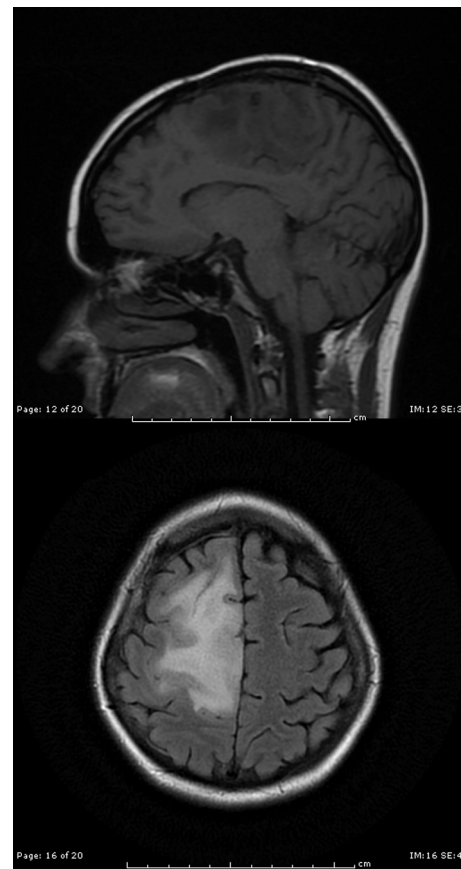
Sagittal T1-weighted (upper) and axial fluid attenuated inversion recovery (lower) MRI showing a non-enhancing lesion in the right posterior frontal region with no calcification and minimal mass effect.
